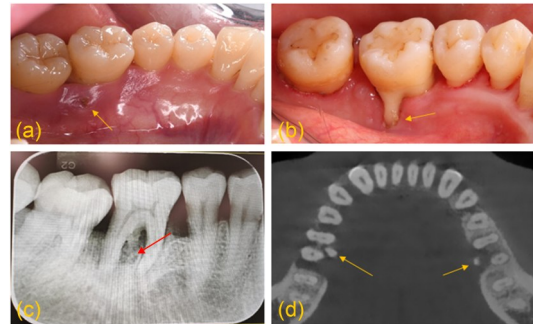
Clinical and radiographic images of mandibular first molars with distolingual roots. (a) Swelling and infection (arrow) of the gingiva at the lingual site; (b) Recession (arrow) of the gingiva at the lingual site; (c) Radiograph of mandibular first molar with distolingual root (arrow); (d) Cone beam computed tomography (CBCT) of mandibular first molars with distolingual root (arrows).
